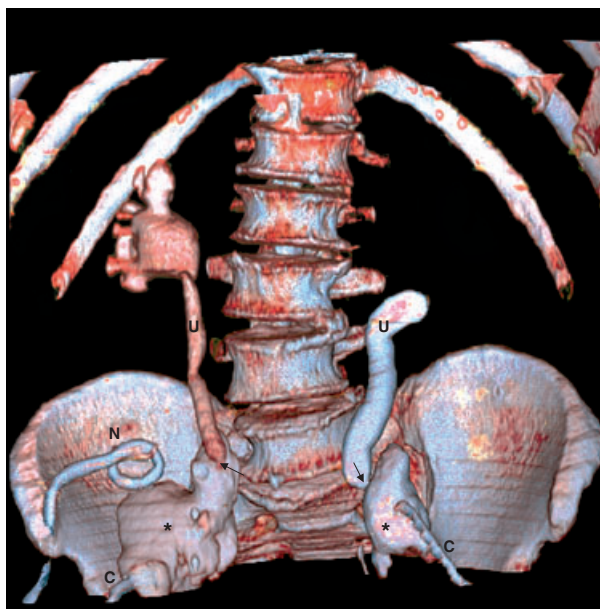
CT scan 3D reconstruction with urinoma opacification. The abdominal CT scan after medium contrast opacification via the drainage catheters (C) discloses two opacified urinoma (asterisks). The two native ureters, which communicate (arrows) with the urinoma are retrogradely opacified. The two native ureters are dilated. Medium contrast material opacify the right kidney, not the left, probably because of less contrast material reflux in the left pyelocalical cavities. No contrast material is seen in the transplanted kidneys. N denotes nephrostomy.
